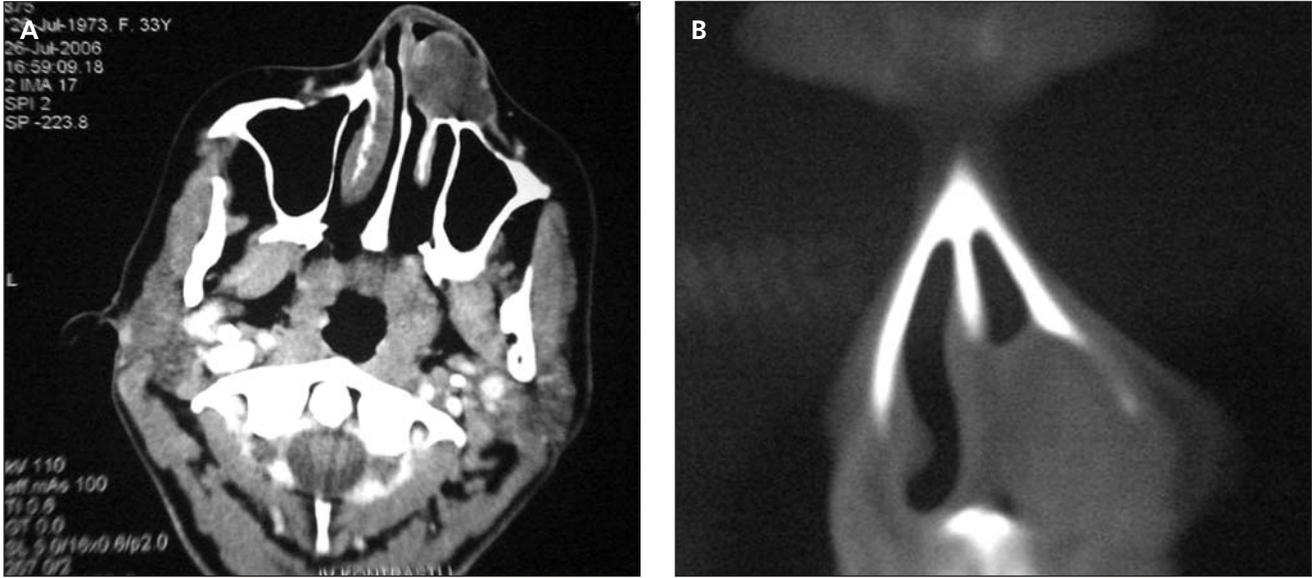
Axial (A) and coronal (B) computed tomographic images of the lesion.
